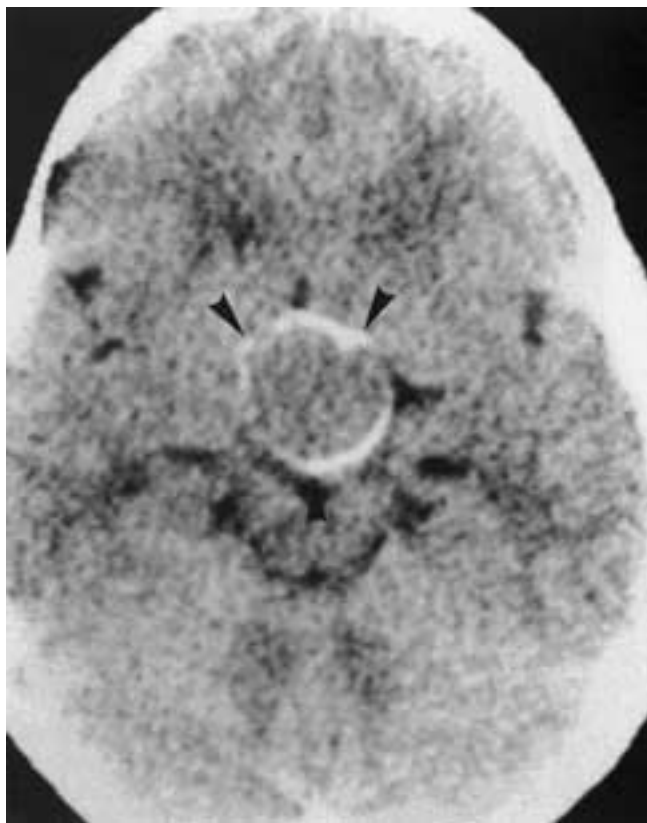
Craniopharyngioma. Axial nonenhanced CT image shows a suprasellar tumor with a peripheral rim of calcification (arrowheads) and a central region that is isodense to brain.
